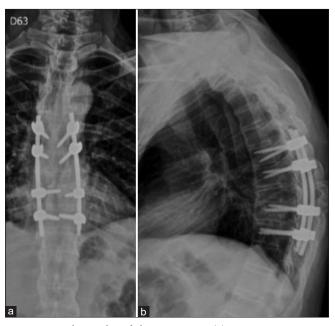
Radiography of thoracic spine. (a) Anterior - Posterior view (b) Lateral view. It observe correct placement of pedicle screws without signs of misplacement or vertebral lysis.
